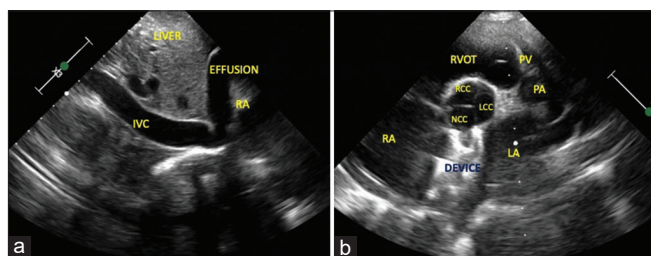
(a) Subcostal long-axis echocardiographic view showed congested inferior vena cava with no inspiratory collapse and moderate pericardial effusion, (b) Parasternal short-axis view with atrial septal defect device impinging on the noncoronary sinus of the aorta. IVC: Inferior vena cava, RA: Right atrium, LA: Left atrium, RVOT: Right ventricular outflow tract, PV: Pulmonary valve, PA: Pulmonary artery, RCC: Right coronary cusp, LCC: Left coronary cusp, NCC: Non-coronary cusp of aortic valve
